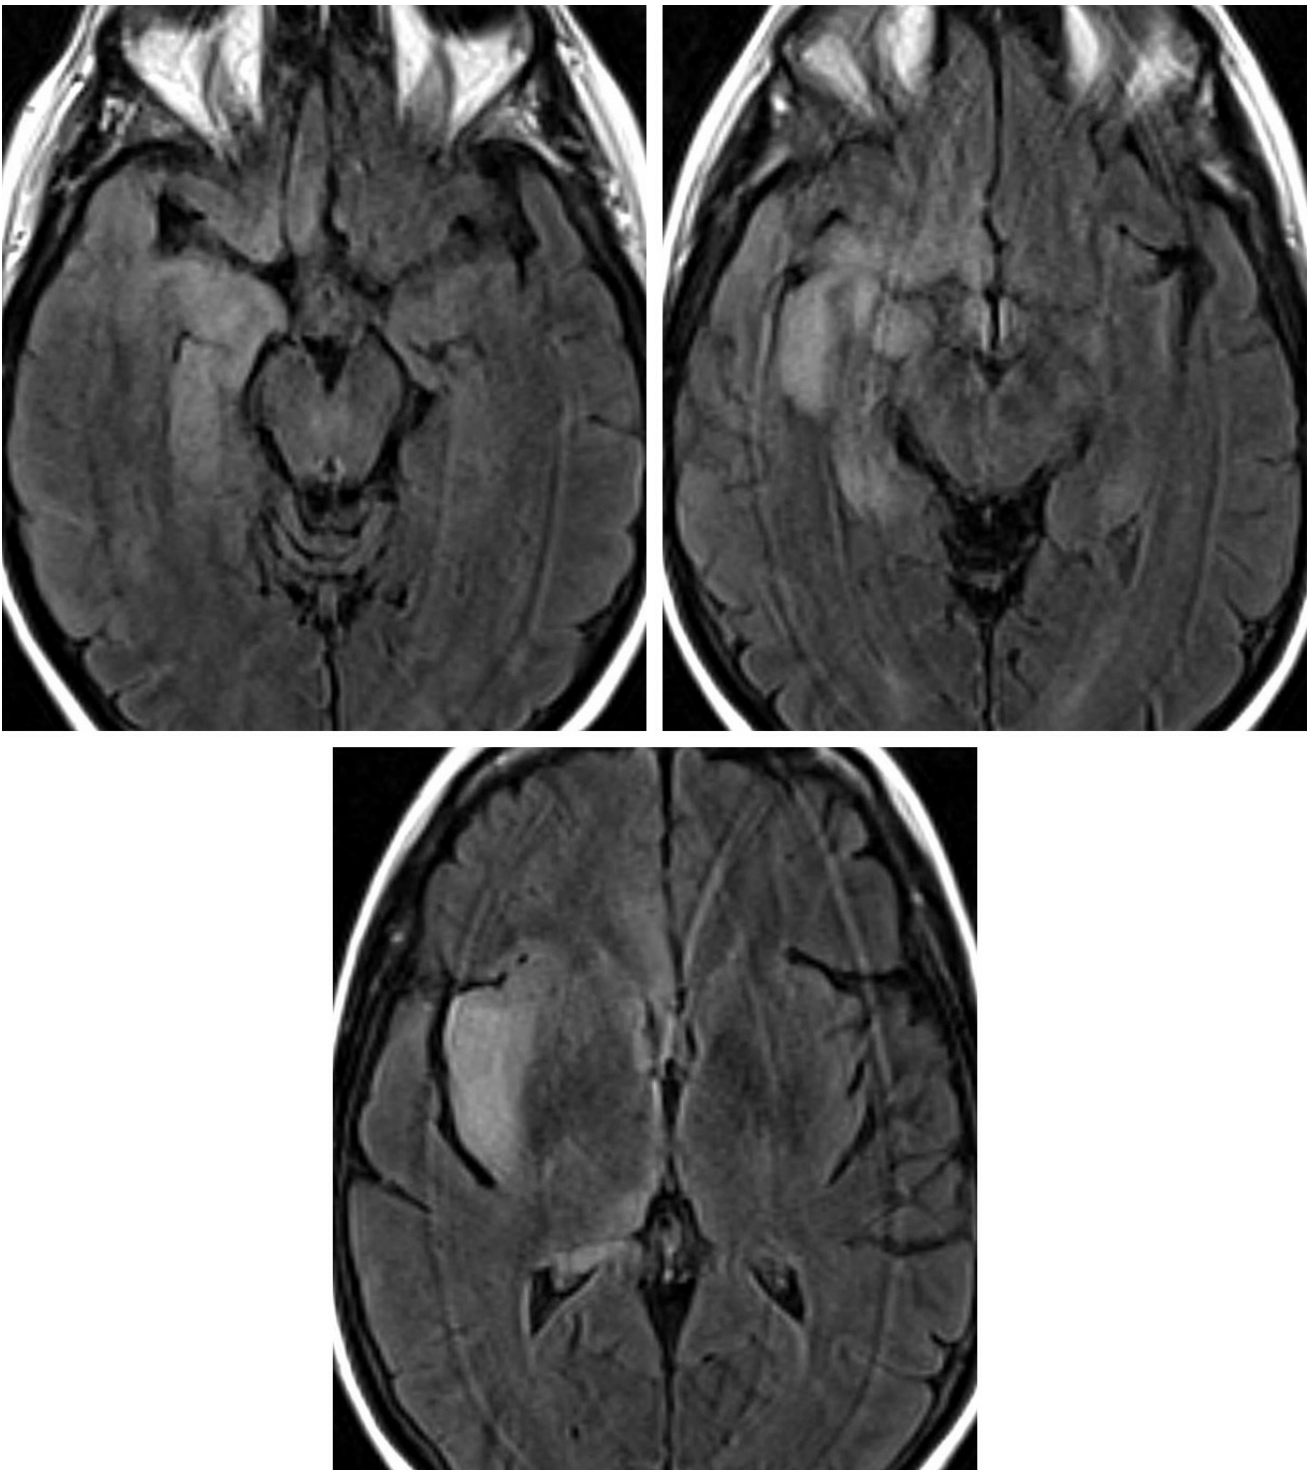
In the same patient as Figure 1, Axial FLAIR MR images demonstrate hyperintense edema involving the cortex and subcortical white matter of the medial anterior right temporal lobe, inferior right frontal lobe and right insular cortex with sparing of the basal ganglia.
